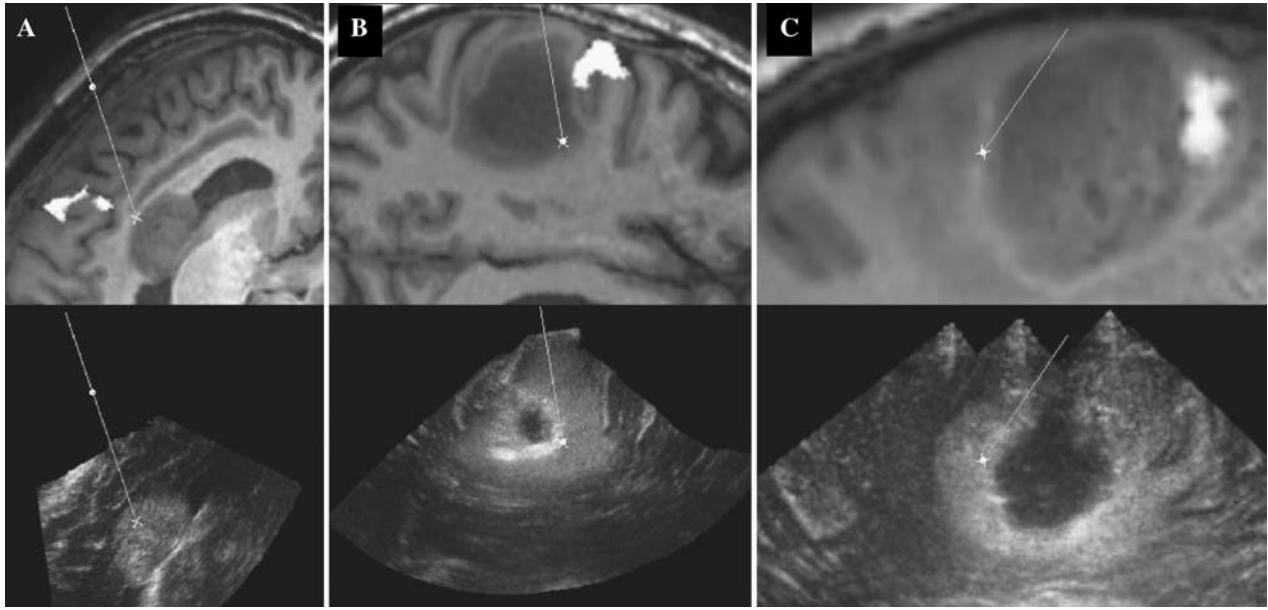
Brain shift detection using corresponding anyplace slices from MRI (top row) and ultrasound (bottom row). Examples taken from different stages are shown; (A) immediately after the first ultrasound volume was acquired (patient #1), (B) when some tumor tissue had been removed (patient #9) and (C) towards the end of the operation when the central part of the tumor had been removed (patient #11)
